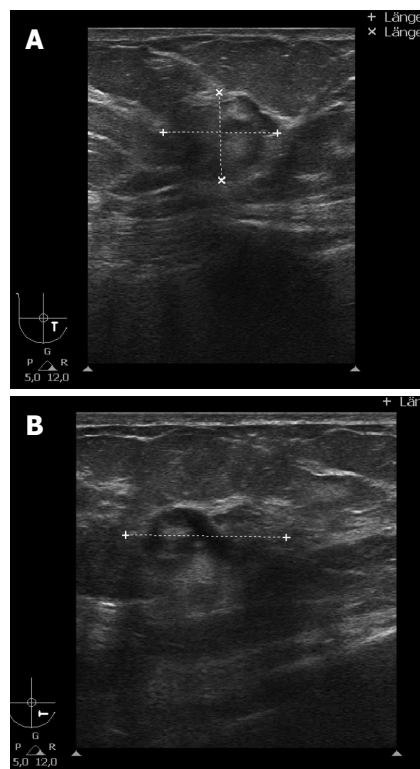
Breast ultrasound shows an irregular structure of complex echogenicity measuring 2.4 cm × 2.0 cm × 1.6 cm (BI-RADS 5) (A and B).
